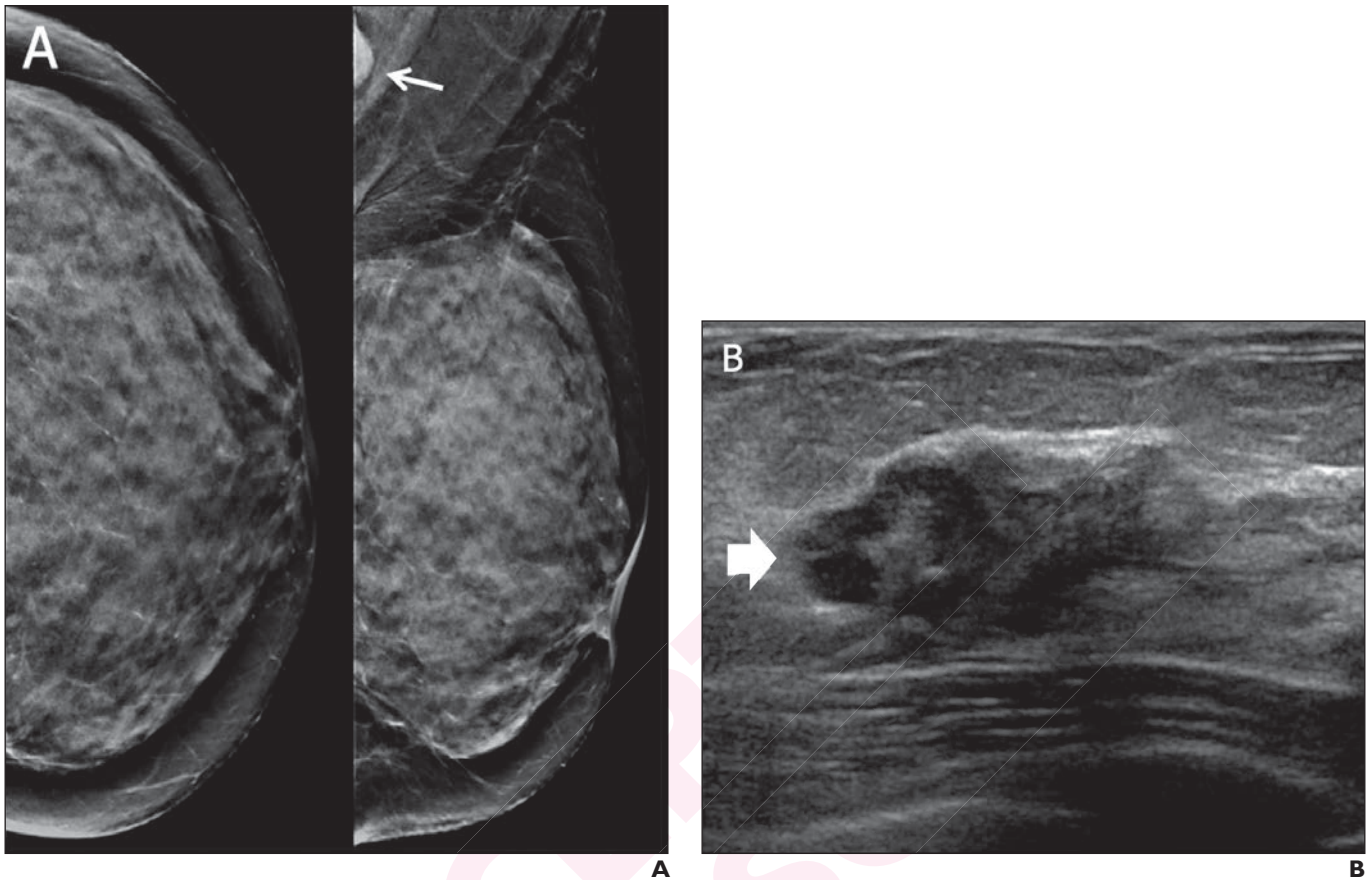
Cancer seen only on screening ultrasound in a 58-year-old woman with extremely dense breasts. A) CC (left) and MLO (right) synthetic 2D mammograms show normal extremely dense parenchyma, interpreted as negative also on DBT. In retrospect, a portion of a dense node is seen in the left axilla (arrow). Technologist-performed handheld screening US was performed bilaterally with standard documentation. B) Radial US image left breast 12:00 6 cm from the nipple shows an irregular, hypoechoic 1.9 cm mass (arrow). US-guided core biopsy showed grade 2 IDC, ER positive, PR negative, HER2/neu amplified by fluorescence in situ hybridization, Ki-67 proliferation index high at 40%. US-guided core biopsy of left axillary node confirmed metastatic disease. The patient had primary chemotherapy with no residual invasive carcinoma and few foci of DCIS at lumpectomy. Targeted axillary dissection (with seed-localized excision of known metastatic node) showed one metastatic node with treatment effect and three normal nodes.
